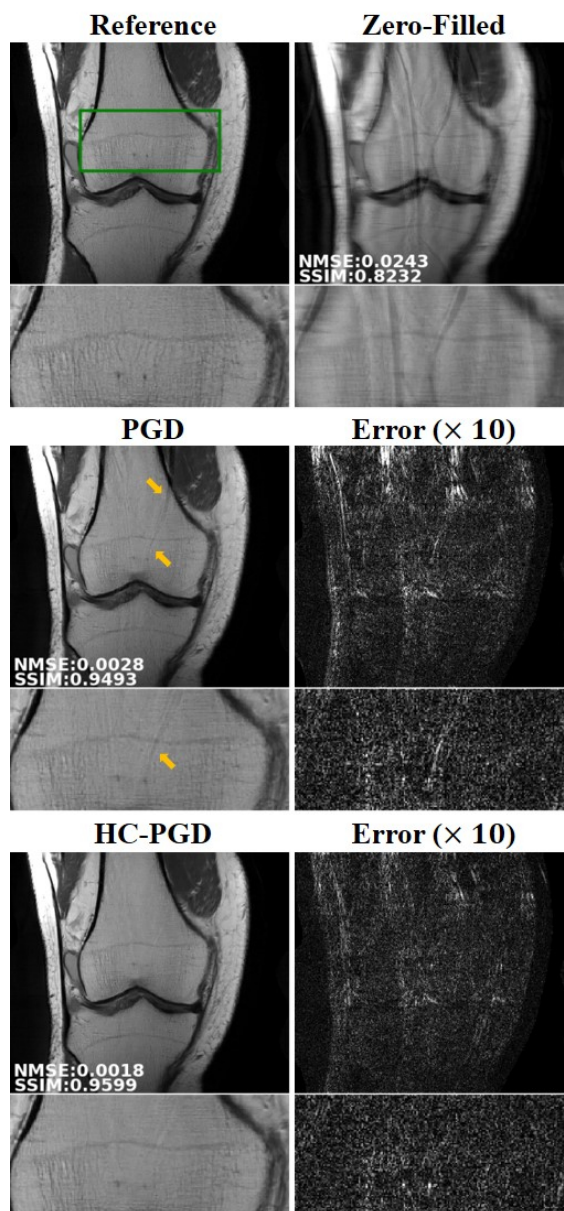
A representative slice from the Coronal PD dataset with 4-fold acceleration rate using a uniform undersampling pattern, reconstructed with DL-MRI reconstruction based on the conventional PGD and the proposed HC-PGD unrolling, as well as error images with respect to the reference fully-sampled image scaled by a factor of 10. Zerofilled image corresponds to the input to the network, $\mathbf{x}^{(0)}$. The green rectangle in the reference image mark the zoom-up area shown in the second and last rows for each method. Residual aliasing artifacts, which are visible in the PGD unrolling results, have been suppressed using the HC-PGD scheme. Improvements in the quantitative metrics, shown on the lower-left corner of the images, also align with these visual observations.
